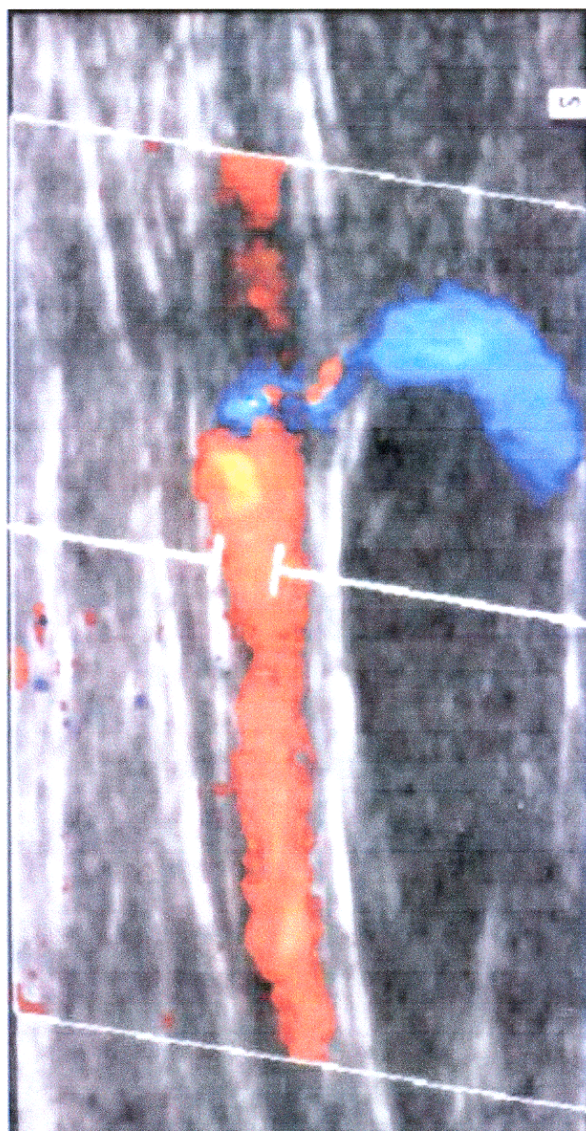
A*, Refluxing great saphenous vein with a tributary as a source of reflux. Actual display was rotated by 90° to mimic the standing position of the patient during the examination. The transducer probe is at the right of the view. *B*, Reflux blood flow signal, above baseline, lasting >1 second as detected by duplex ultrasound scan.
